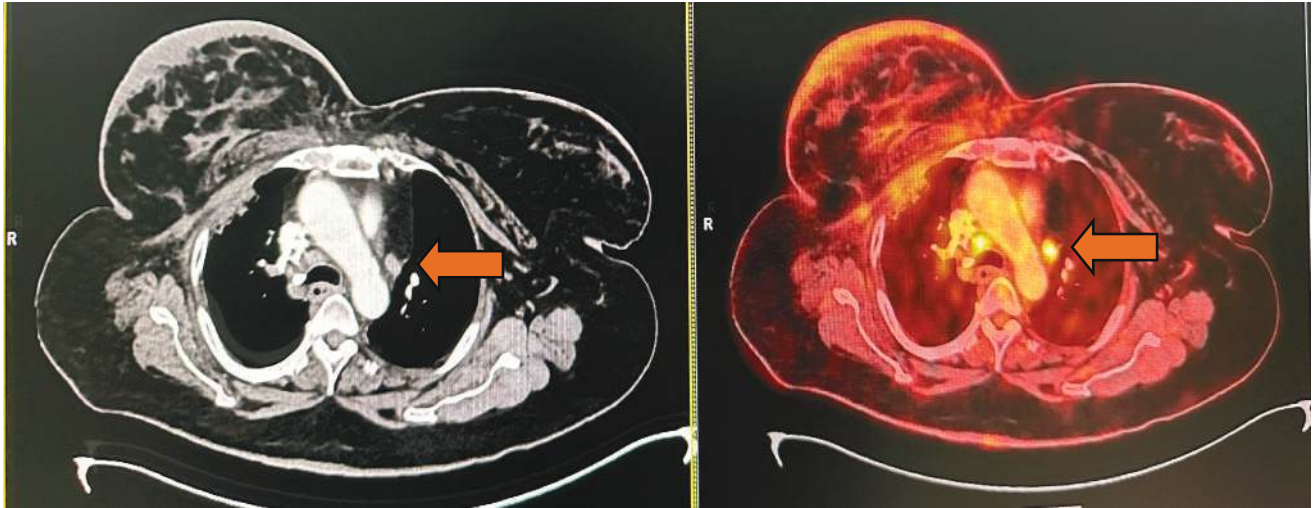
Enlarged FDG avid (SUV: 9.26) mediastinal lymph nodes in a 59 year old woman, suggesting nodal infiltration from treated primary breast cancer (orange arrow). Post operative and post radiation changes are also noted in right breast.
